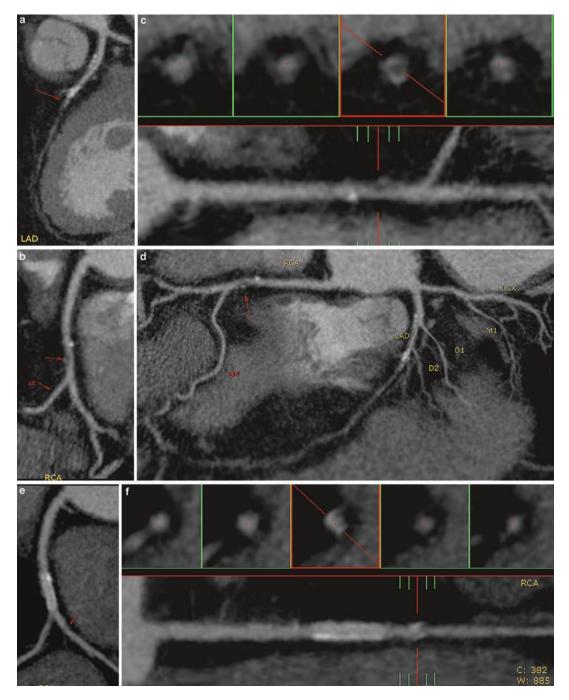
(a) cMPR LM–LAD: Mid-left anterior coronary artery (LAD) chronic total occlusion (*arrow*). (b–d) RCA cMPR, stretched, and 2D MAP: Mid-RCA high-grade stenosis (*arrow*). (e–g) RCA cMPR, stretched, and 2D MAP: Repeat CTA at 11 months: patent stent in the mid-RCA. New high-grade stenosis in the distal RCA
